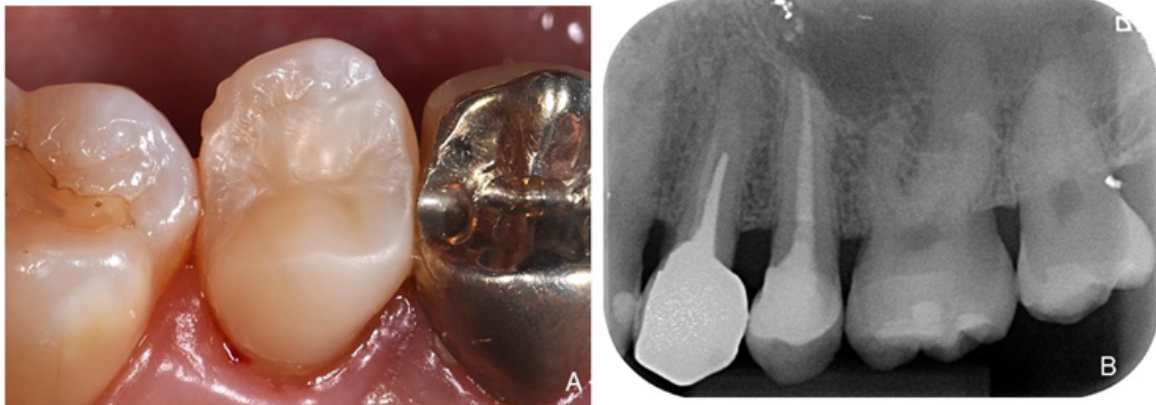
A) Clinical evaluation after 4 months. B) Radiographic evaluation.
